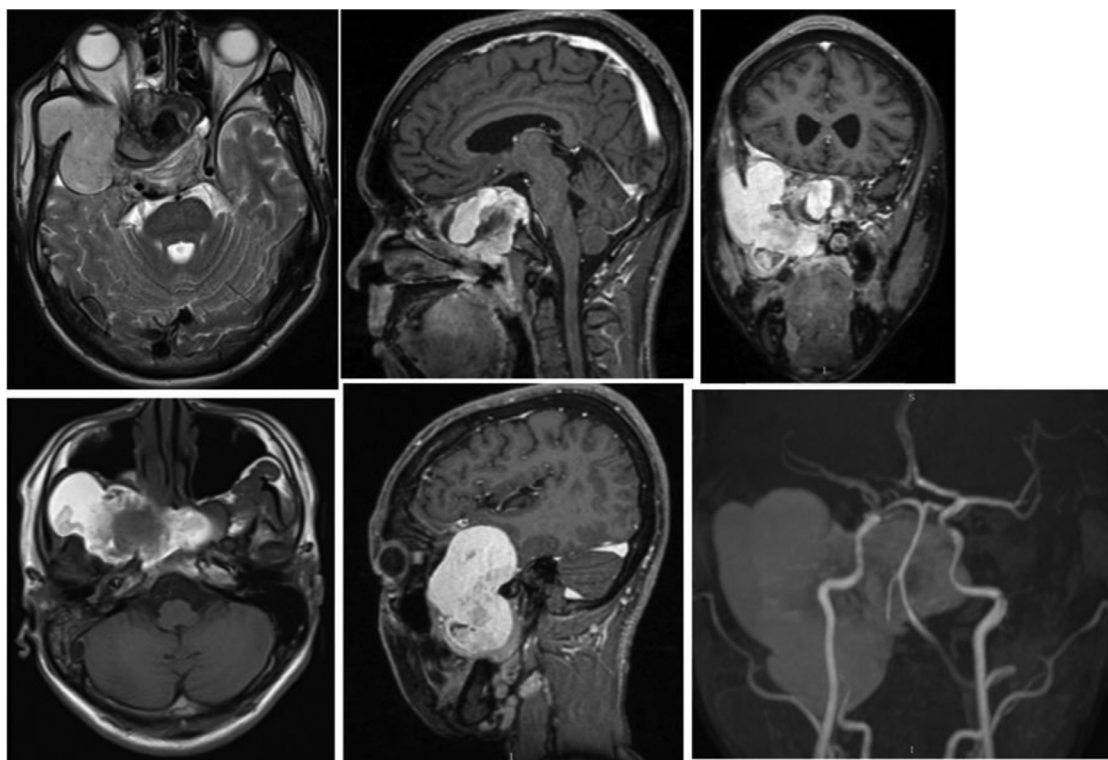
MRI revealed a giant pseudoaneurysm of the right internal carotid artery in cavernous sinus, 40 x 25 mm in size, with partial thrombus surrounded by a heterogeneous density soft tissue in the right pterygopalatine fossa, spreading to temporal fossa, 86x57mm in size, non-contrast enhancement, which was likely a solid fluid collection.
